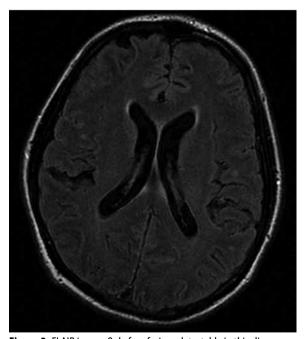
FLAIR image. Only four foci are detectable in this slice as hyperintense lesions.
